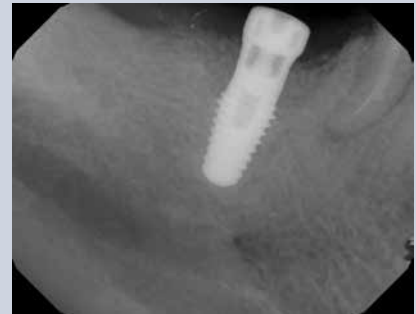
Radiograph of the 46 implant after implantoplasty with bone graft in place.
